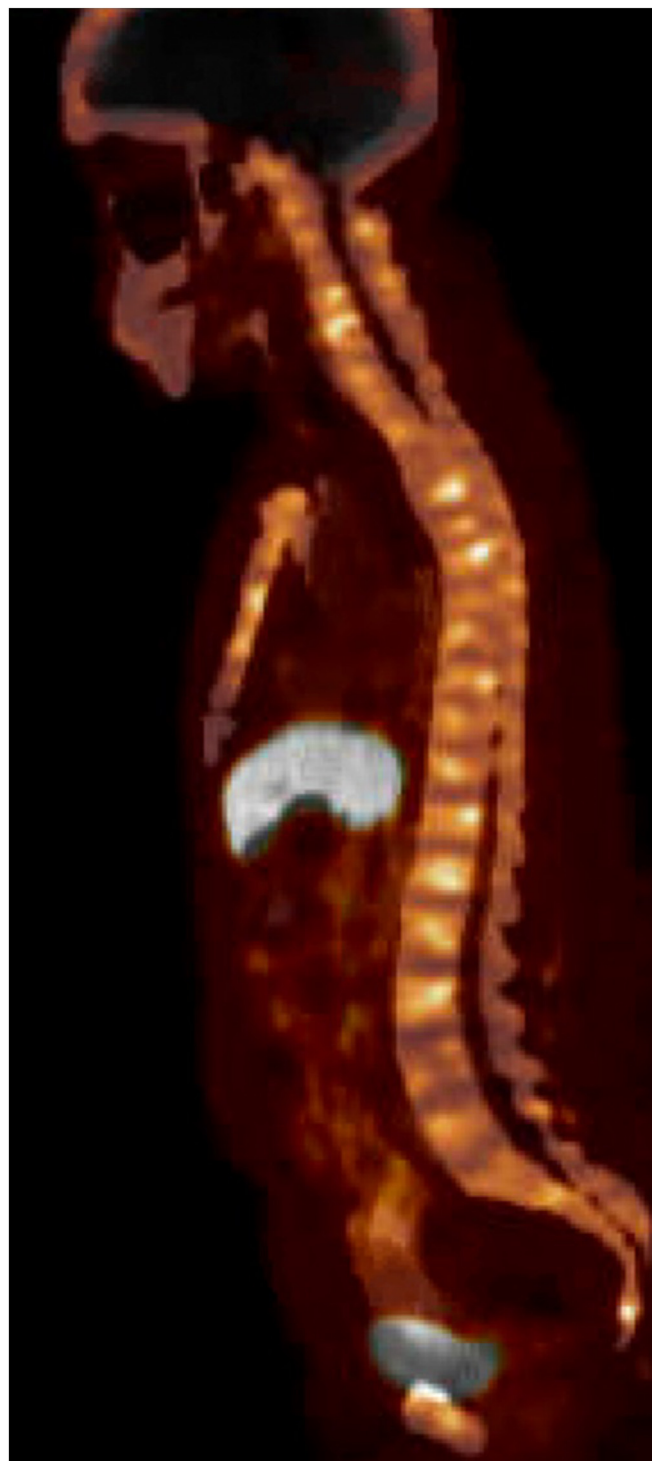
Ga-68-DOTA PET/CT with innumerable DOTATATE avid lesions along the bones. CT = computed tomography.
